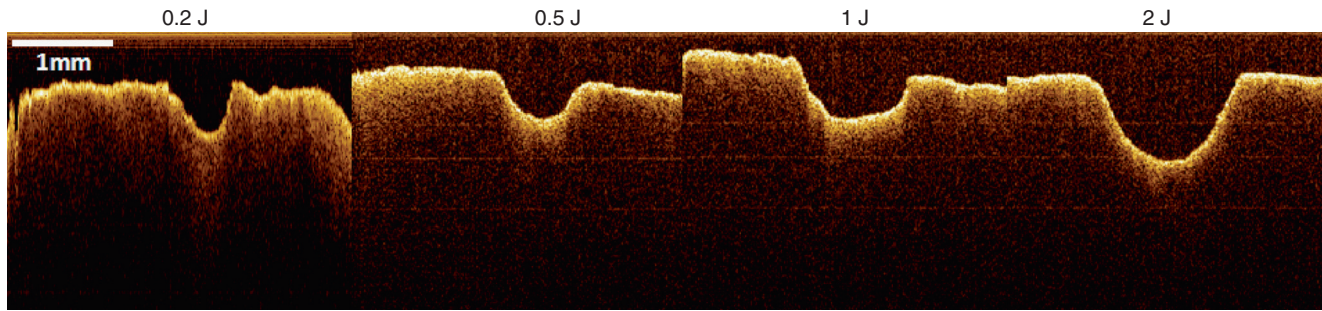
Cross-sectional optical computed tomography images of ablation craters: The demonstrated stone is uric acid
